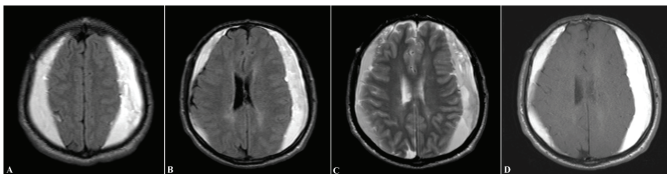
A, B, C. FLAIR and T2-weighted images reveal hyperintense signal in the subdural space with slight hypointense areas. D. T1-weighted images reveal hyperintense signal in the subdural space. Additionally, effacement is observed in both lateral ventricles, which is more prominent on the left side
